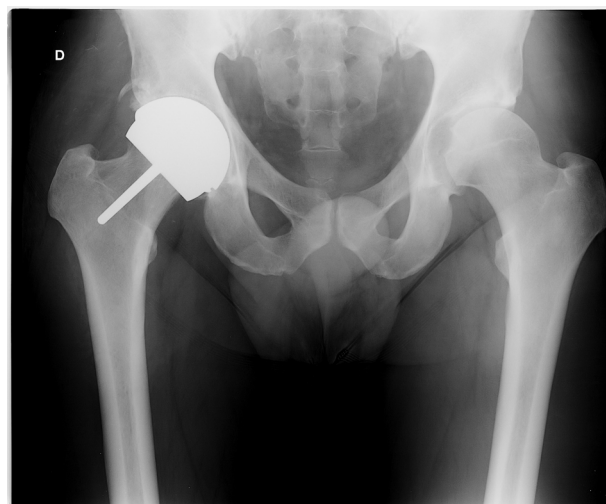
Postoperative 4 year AP X-ray of the pelvis. Frontal plane cup inclination is 43°, the cervico-diaphyseal angle is 130° and the SSA angle is 132°. There are no radiolucencies.
